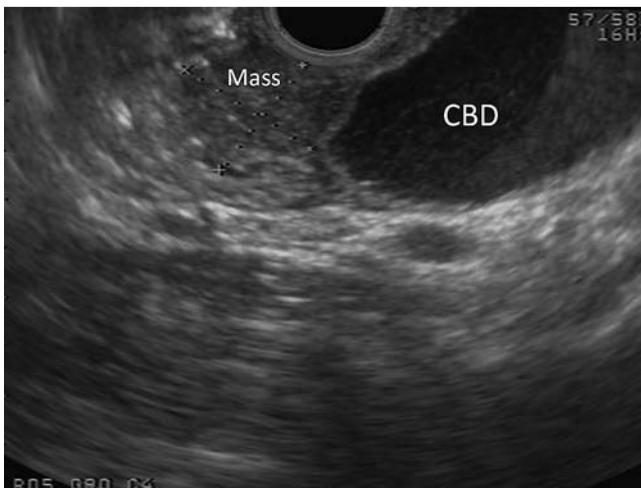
Endoscopic ultrasound (EUS) view of the lesion in [Fig. 4](#). The subepithelial lesion obstructs both the common bile duct (CBD) and pancreatic duct, and was staged as T3N1 on this examination.
